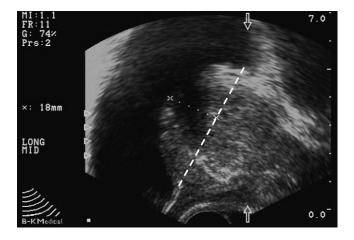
Measurement of IPP via transrectal ultrasonic imaging
